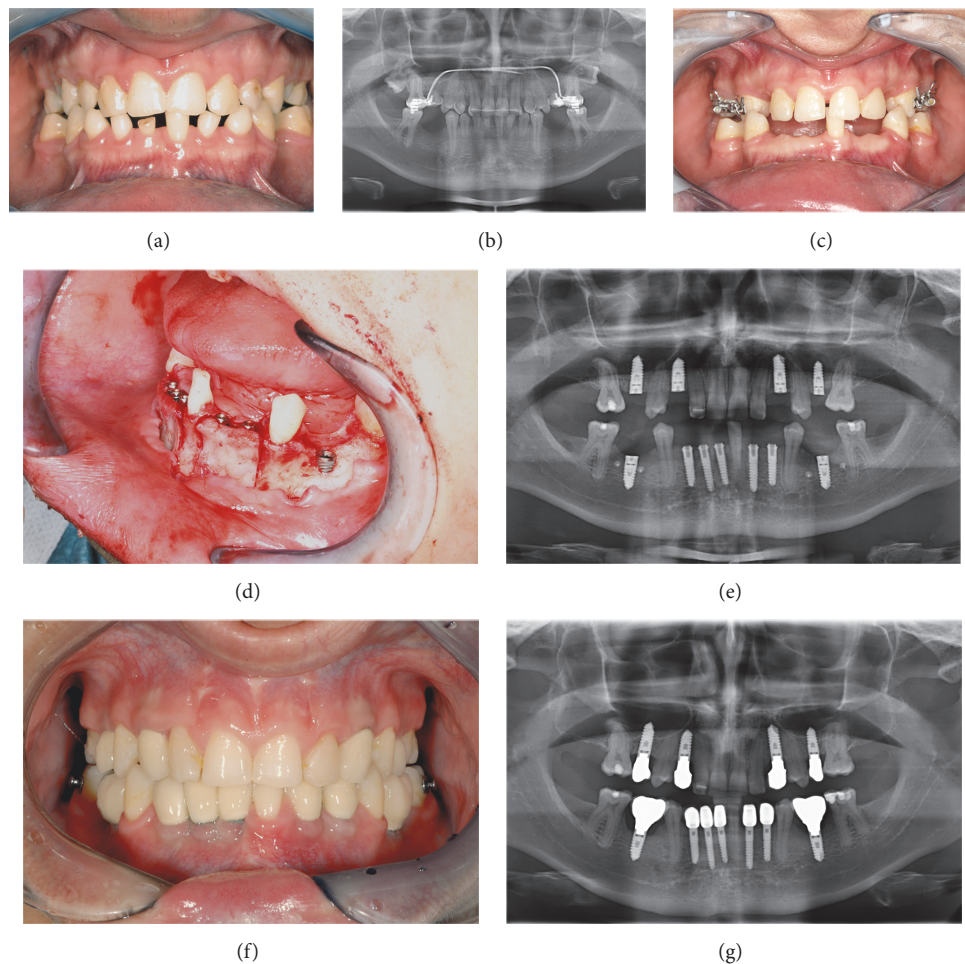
Treatment procedures of patient with oligodontia until oral rehabilitation. (a) Initial condition, patient with oligodontia (13 teeth absent). (b) Panoramic X-ray of the initial case. (c) After deciduous tooth extraction. (d) Intraoperative surgical view, insertion of implant and bone splitting. (e) Postoperative panoramic X-ray showing implant position. (f) Prosthetic rehabilitation with single tooth crowns. (g) Panoramic X-ray, 3 years after implantation.
